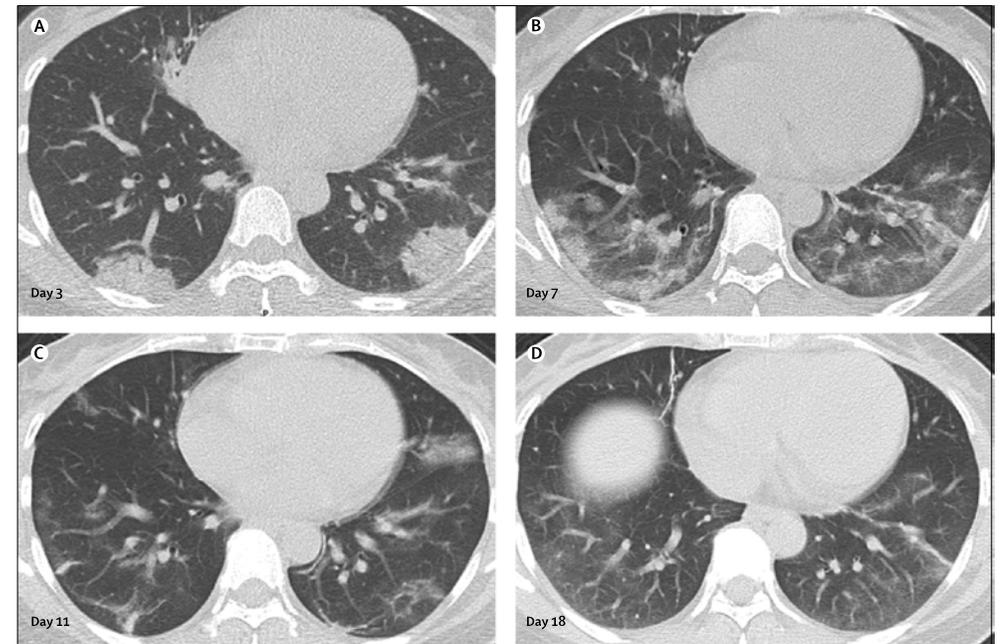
Transverse thin-section serial CT scans from a 42-year-old woman
